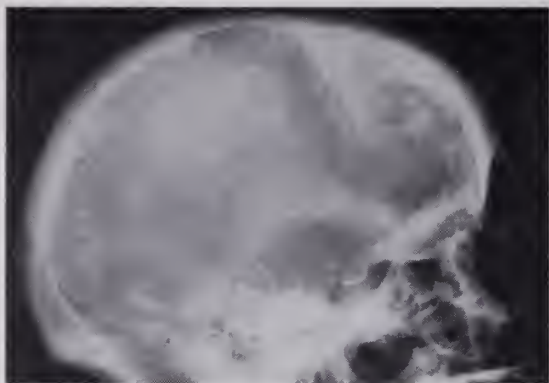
Skull x-ray showing sclerotic densities.
